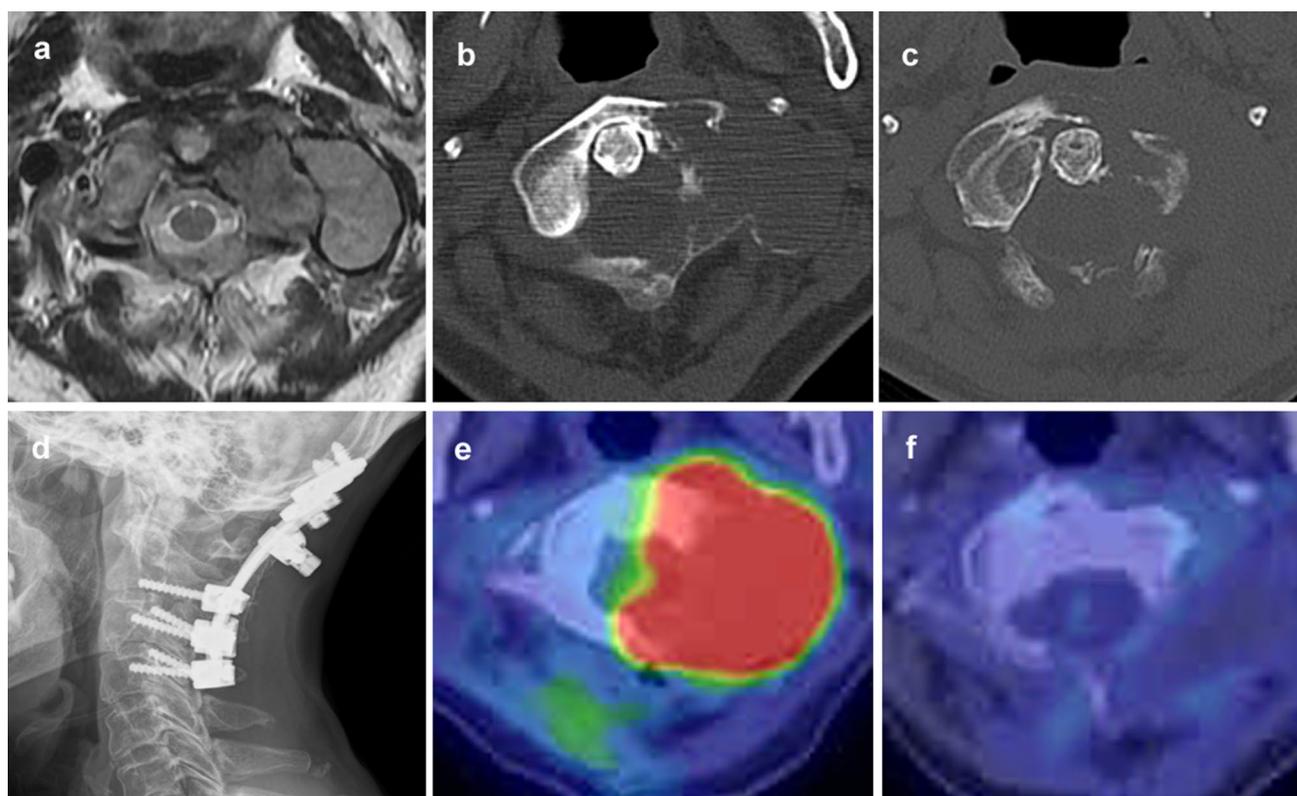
A 73-year-old woman with spindle cell sarcoma of high-grade malignancy. a Axial T2-weighted MRI showing a neoplastic lesion on the left side of C1; b osteolytic destruction of the left part of the C1 observed on CT imaging; c after completion of CIRT, an aggravation of destruction and fracture of C1 seen on CT imaging; d solid
